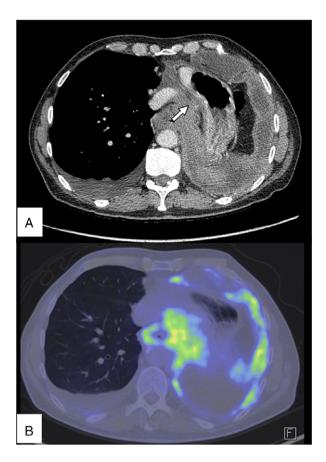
Positron emission tomography-computed tomography (PET-CT) showing thickened and metabolic active left pleural lesions close to the oesophagus, arrow indicates site of biopsy.
